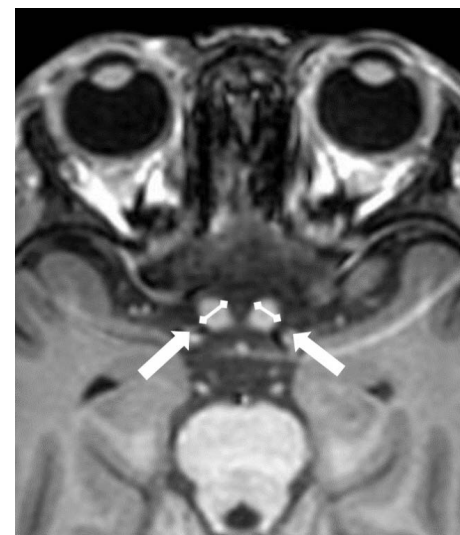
An axial T1-weighted image of a 3-year-old child with MLD. The prechiasmatic optic nerve whit arrows was measured perpendicular to the long axis. Optic nerve hypertrophy was considered when the optic nerve was measured more than 4 mm.
